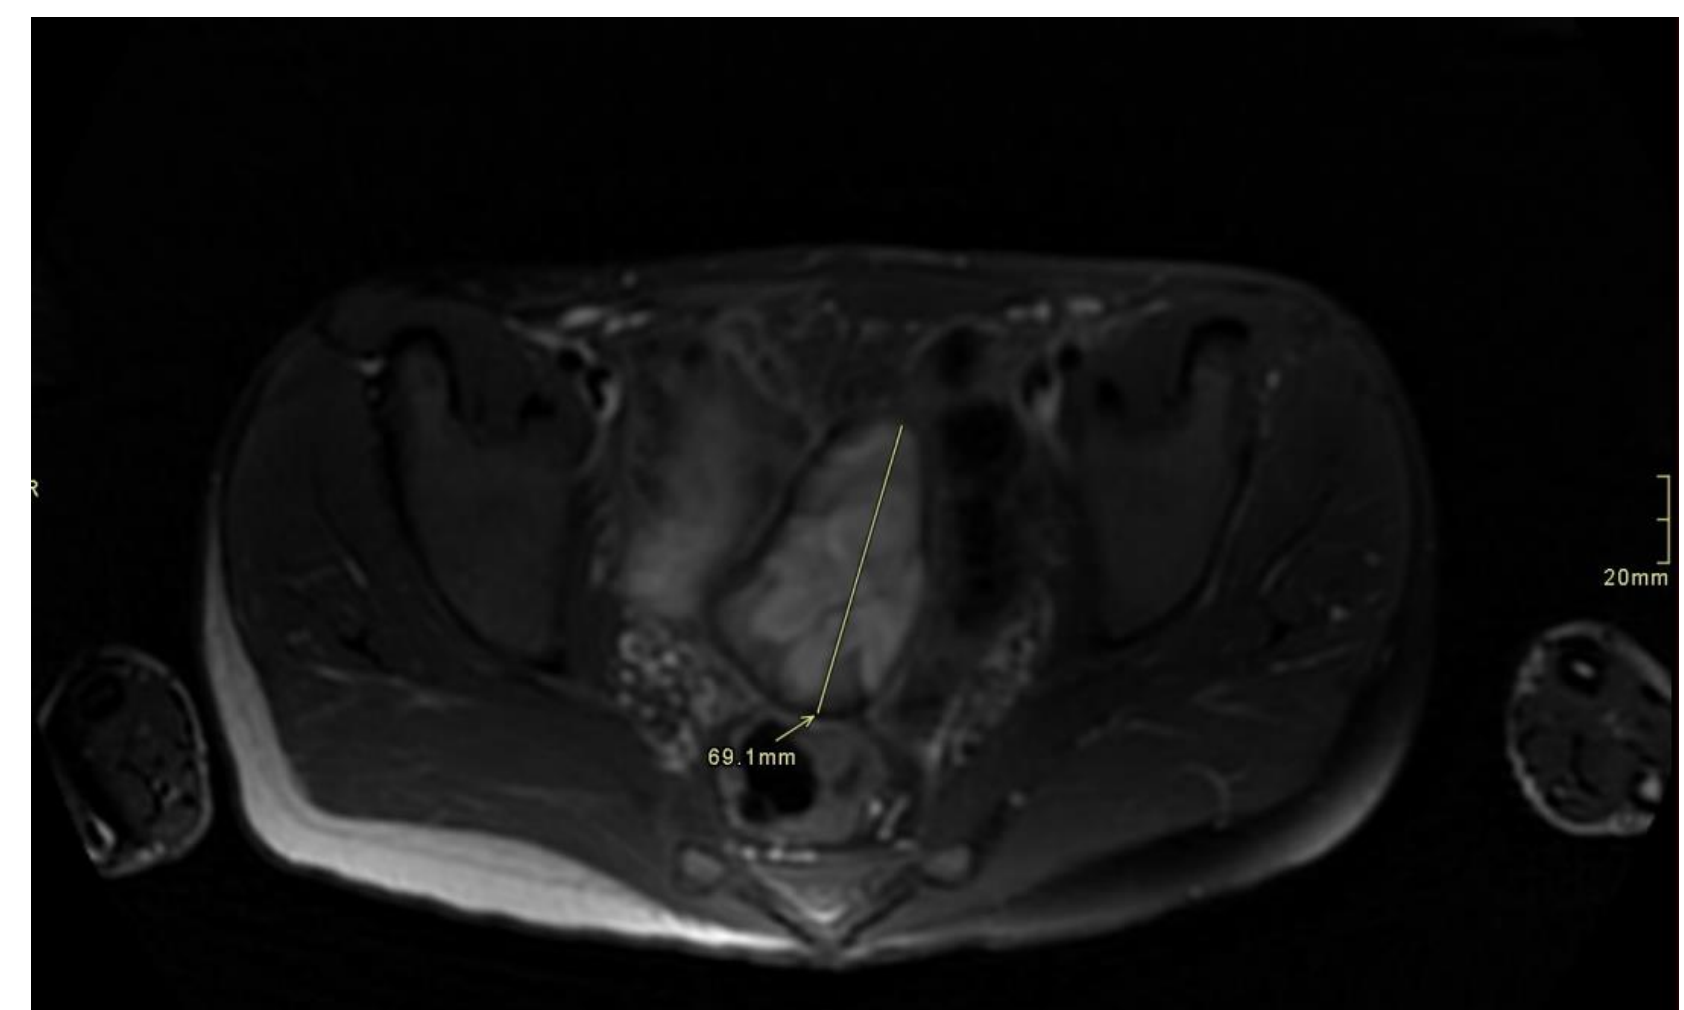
MRI showing a large annular mass involving the terminal ileum
